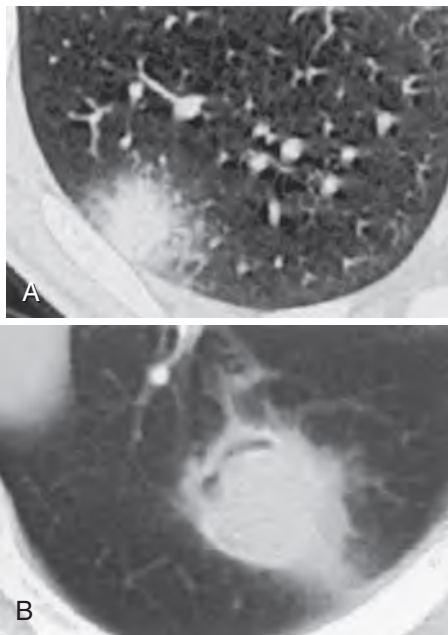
Computed tomography of chest. (A) "Halo" sign of low attenuation surrounding a nodular lung lesion detected in early pulmonary aspergillosis. (B) "Air-crescent" sign in a nodular lung lesion found in late disease. (Radiographs courtesy Dr. Reginald Greene.)
